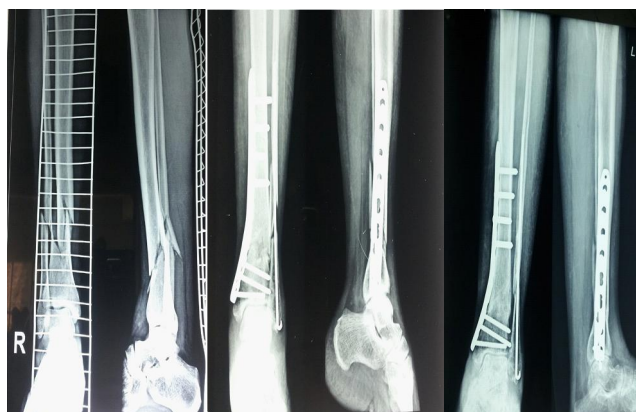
(a). Preoperative radiograph of another patient. (b). 4 week Post op radiograph of the same patient. (c). 12 months post op radiograph of same patient.
